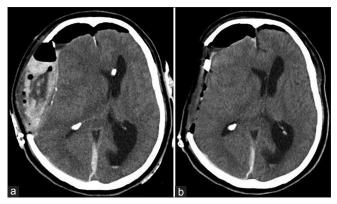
CT imaging findings after first and second surgeries.A large subcutaneous hematoma again appears with midline deviation on postoperative day I after the first surgery (a). Complete removal of the hematoma (b)
